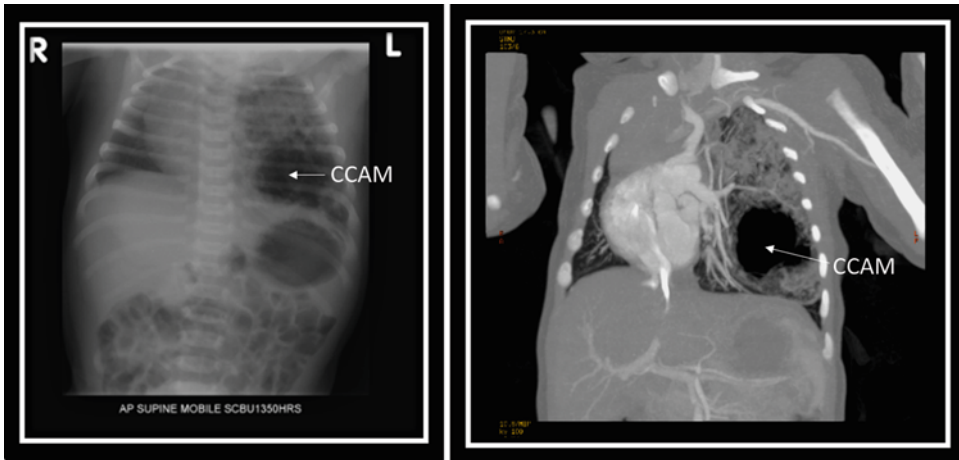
Chest radiograph and CT scan showing left lower lobe CCAM
